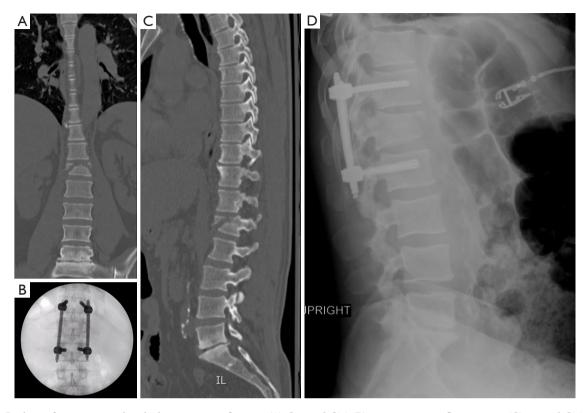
L1 burst fracture treated with short-segment fixation. (A) Coronal CT; (B) intra-operative fluoroscopy; (C) sagittal CT; (D) post-operative lateral X-ray.
